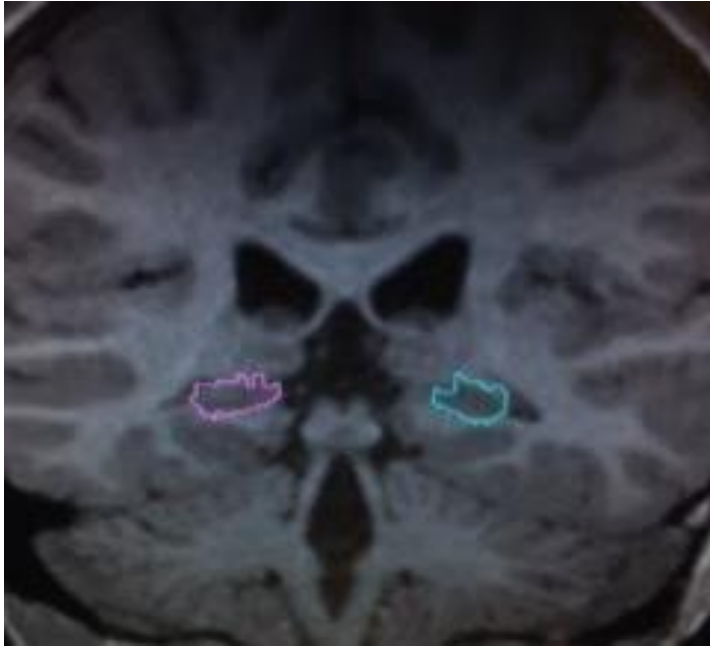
First slice of right/left middle hippocampus before disappearance of pulvinar; MRI scan; coronal view
